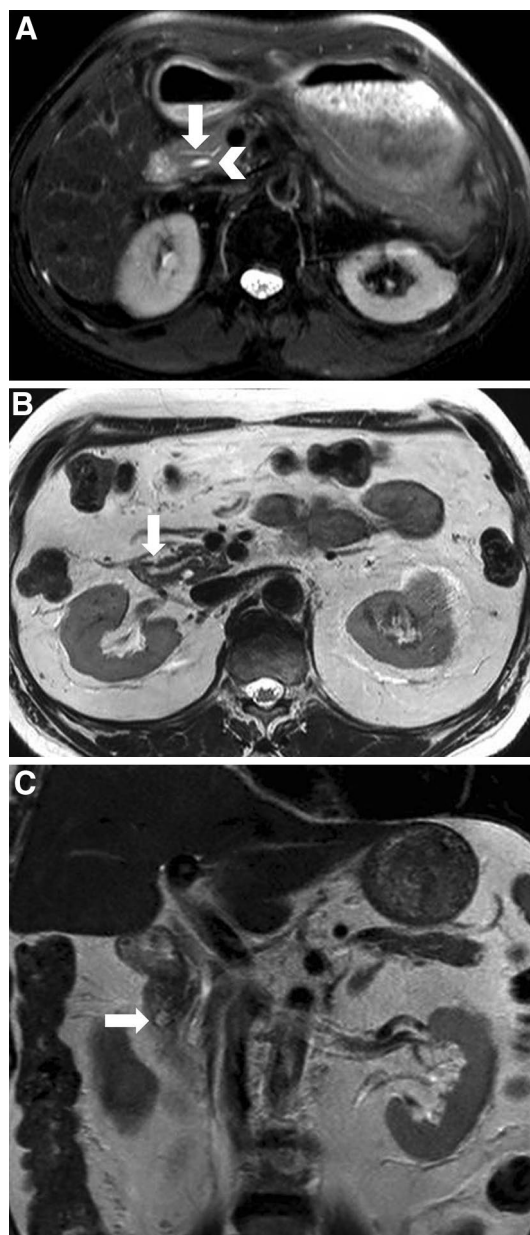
Pancreas divisum in two different patients. a Axial T2-weighted MR image in 43-year-old woman shows main pancreatic duct (*arrow*) passing anterior to common bile duct (*arrowhead*). b, c Axial and coronal MR images show separate draining of dorsal and ventral duct consistent with pancreatic divisum. There is a small focal dilatation of the dorsal duct near the minor papilla, namely Santorinicele (*arrow*)
